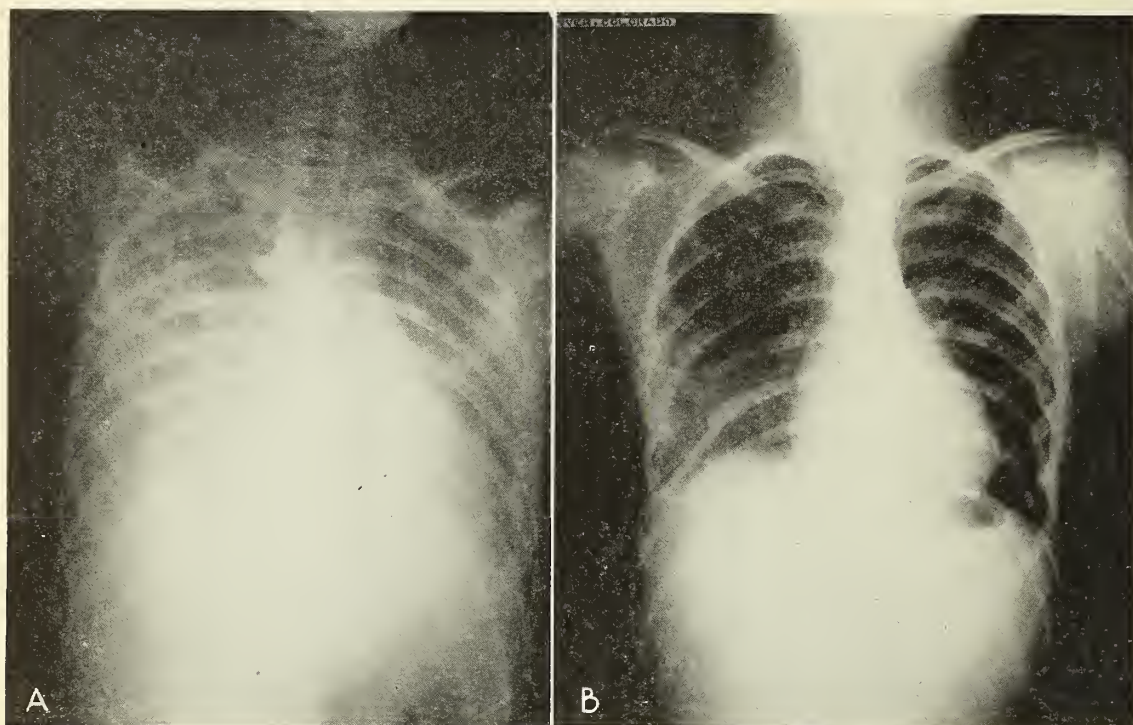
x-ray taken December 3, 1936; B, x-ray taken December 6, 1936
